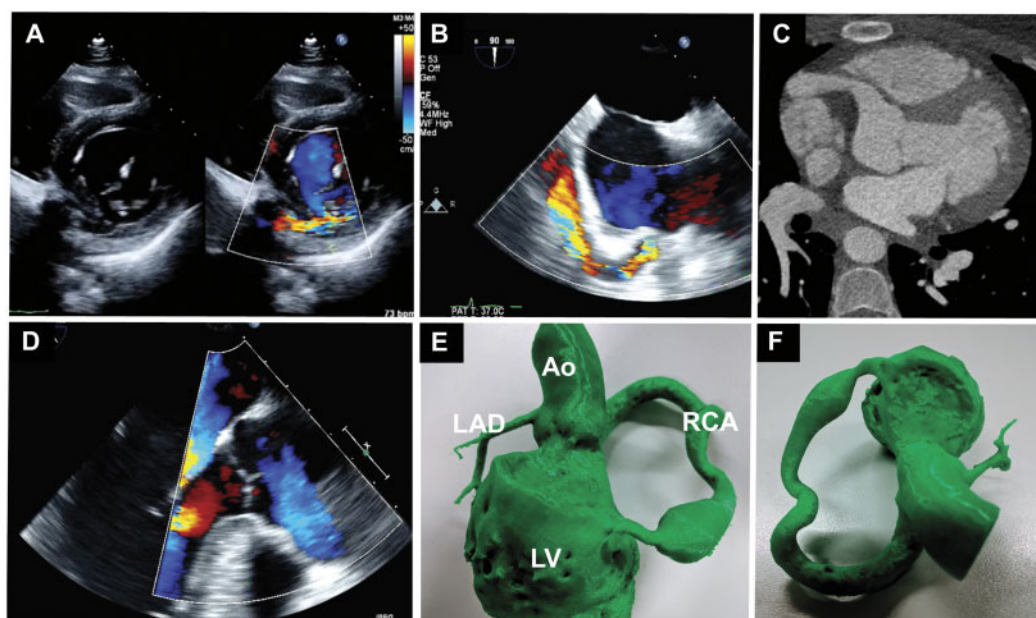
(A) Transthoracic echocardiogram short axis at the mitral valve demonstrating turbulent flow of the fistula with colour-flow Doppler. (B) TOE bicaval view highlighting the fistula size and location with colour-flow Doppler. (C) Cardiac computed tomography axial view demonstrating a severely dilated right coronary artery. (D) TOE long axis view with colour-flow Doppler highlighting the enlarged right coronary artery ostium. (E and F) Annotated three-dimensional printed model clearly depicting the size, course, and anastomosis of the fistulous right coronary artery.
